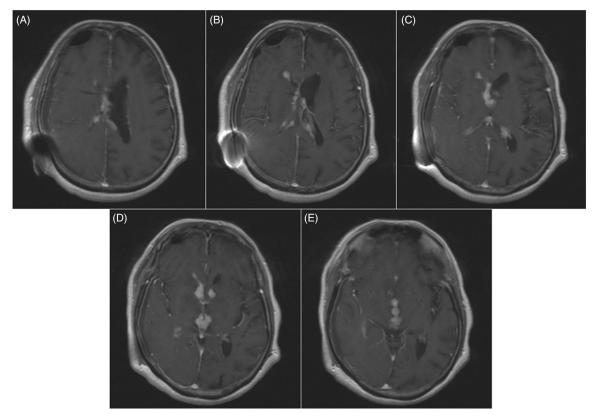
Postoperative axial MRI study (T1 with gadolinium) displaying subependymal nodular enhancement along the ventricular system.
